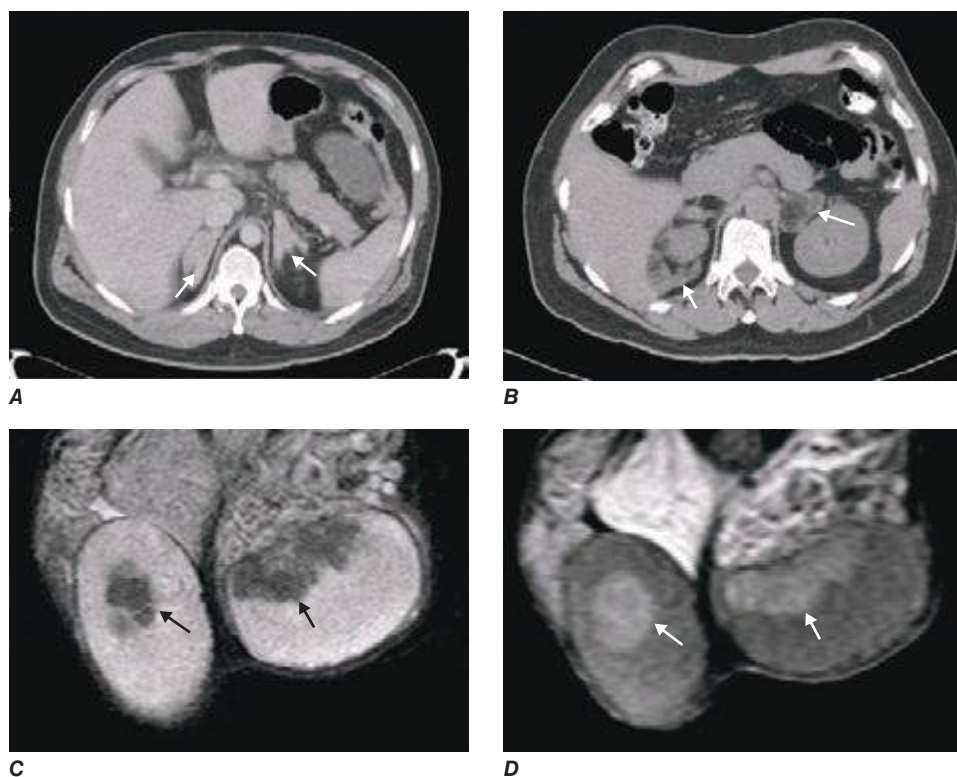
Imaging in congenital adrenal hyperplasia (CAH). Adrenal computed tomography scans showing homogenous bilateral hyperplasia in a young patient with classic CAH (A) and macronodular bilateral hyperplasia (B) in a middle-aged patient with classic CAH with longstanding poor disease control. Magnetic resonance imaging scan with T1-weighted (C) and T2-weighted (D) images showing bilateral testicular adrenal rest tumors (arrows) in a young patient with salt-wasting congenital adrenal hyperplasia. (Courtesy of N. Reisch.)
